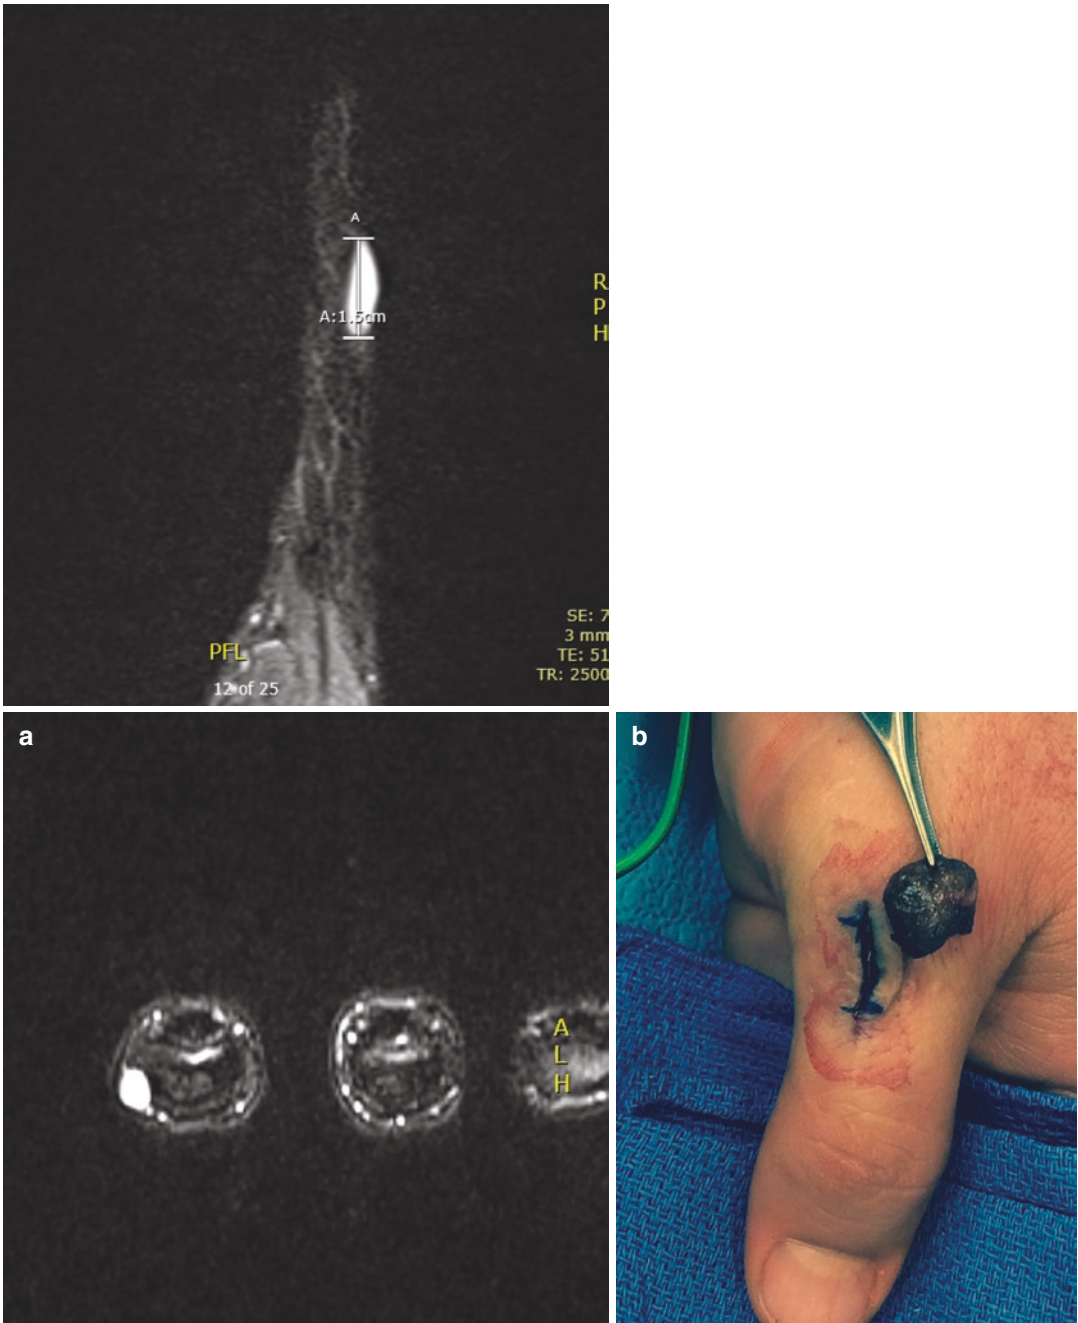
(a) MRI imaging of vascular malformation showing characteristic hyperenhancing T2-weighted mass. (b) Vascular malformation on dorsal thumb being surgically excised
